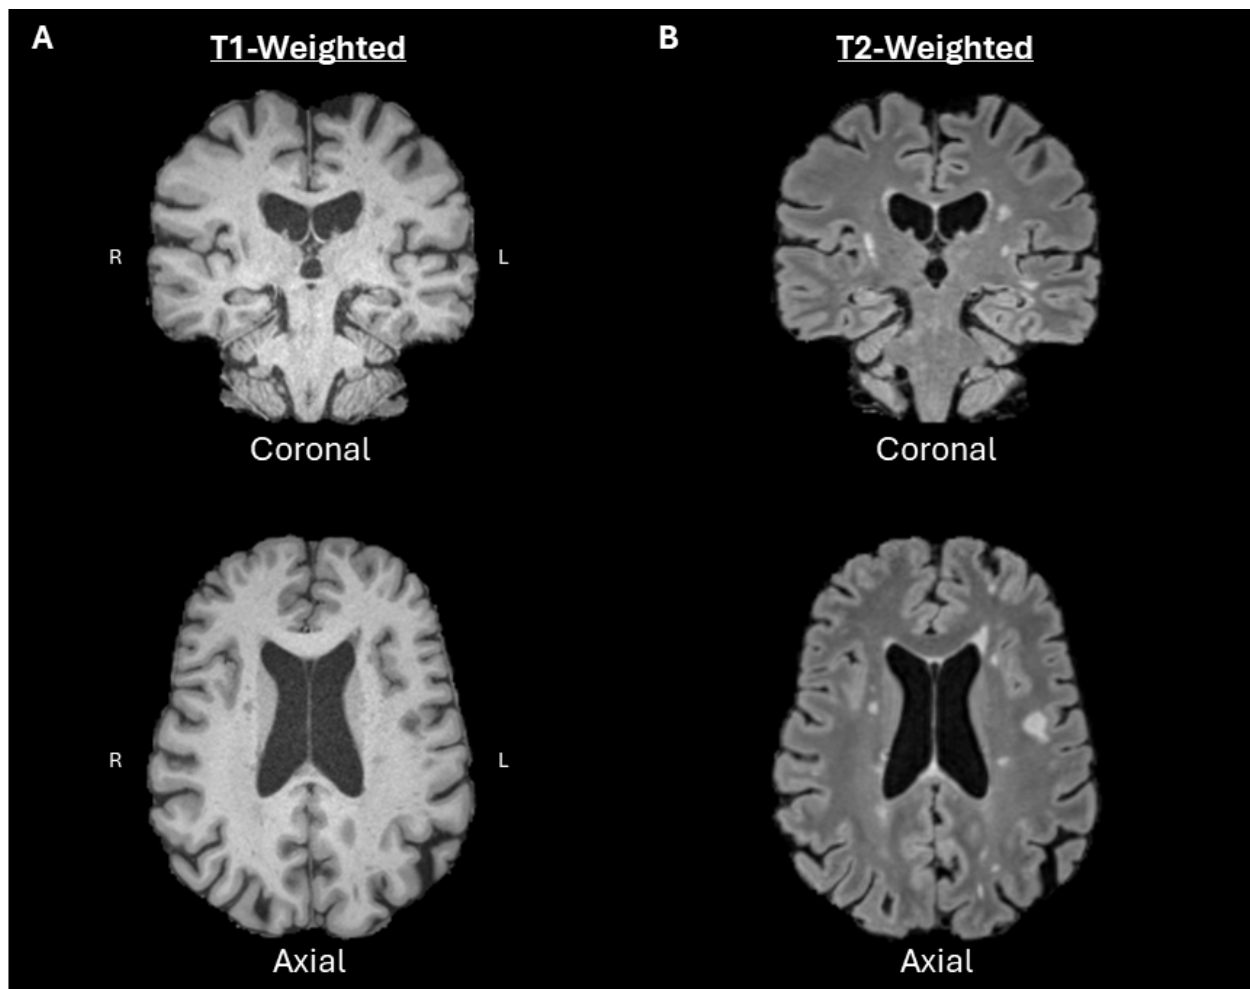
Example T1- and T2-Weighted MRIs in Multiple Sclerosis. Structural brain images highlighting differences in tissue contrast between MRI sequences. a) T1-weighted image from an individual with MS, shown in coronal (top) and axial (bottom) views, with lesions appearing hypointense. b) T2-weighted FLAIR image from the same individual, shown in coronal (top) and axial (bottom) views, with MS lesions appearing hyperintense.
